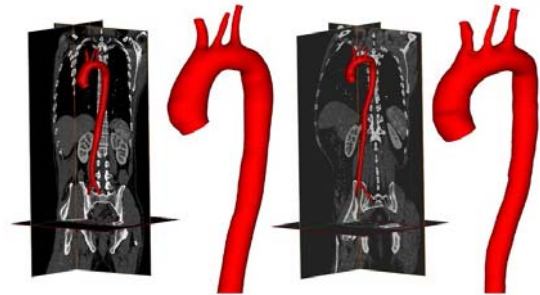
CTA images and three-dimensional aortic geometry.
